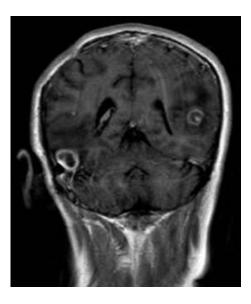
The ring enhancing eccentric target sign on post contrast T1 weighted MRI.
